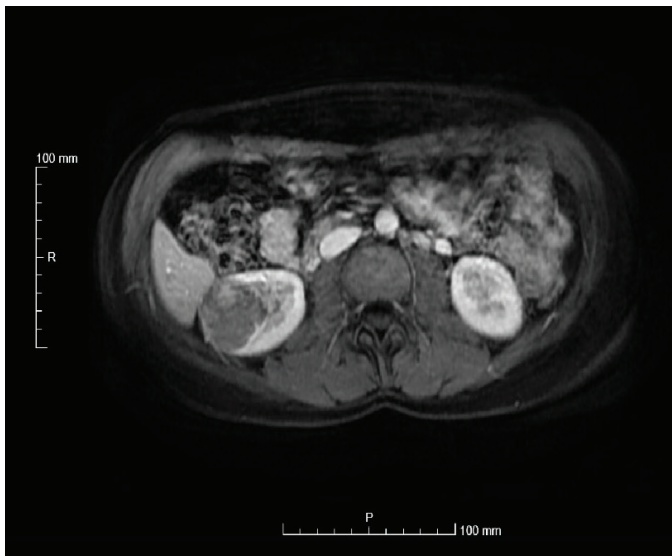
Magnetic resonance imaging findings of the right renal mass. Minimal heterogeneous contrast uptake is visualised on axial contrast-enhanced T1-weighted images
